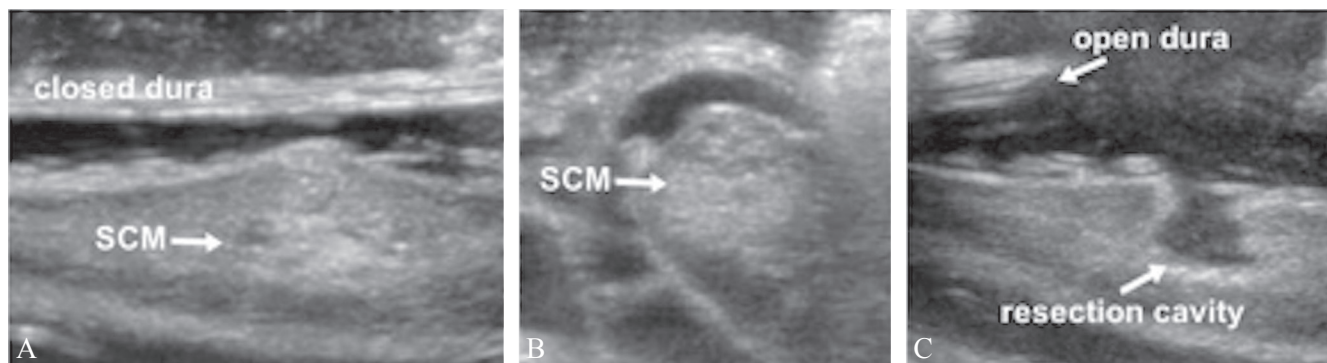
A 46-year-old woman with an SCM at the level of C2-3 (case #20; operative group) sagittal (A, C) and axial (B) intraoperative high frequency ultrasound. The patient showed subacute symptoms (1 month) and underwent a right unilateral laminectomy of C 3 and extirpation of the lesion.
